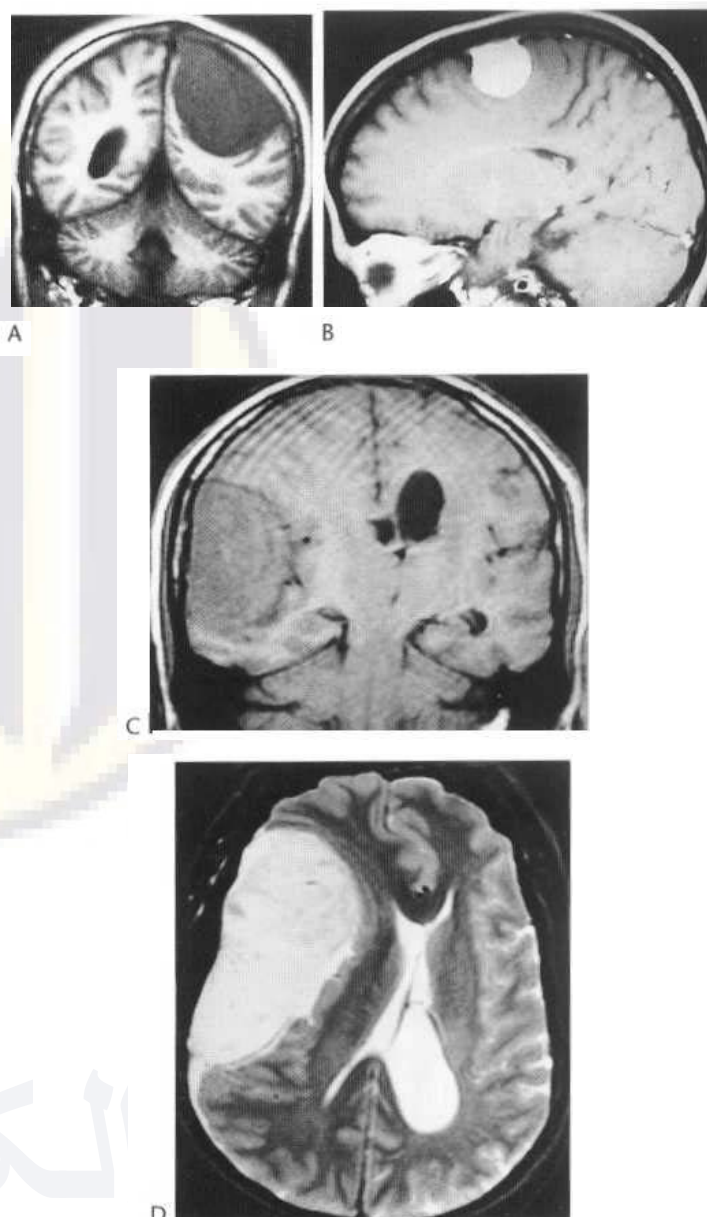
(A) Coronal MRI section (T₁-weighted) shows uniformly low signal of a large parasagittal meningioma. (Courtesy of Dr Gordon Thomson and Bristol MRI Centre.) (B) Sagittal MRI study (T₁-weighted). A small parasagittal meningioma shows strong uniform enhancement with gadolinium. (C) Coronal MRI, T₁-weighted, shows low signal from large meningioma, broadly based on dura and with lower signal rim at brain-meningioma interface. (D) Axial view of same large tumour, T₂-weighted, shows inhomogeneous high signal.
